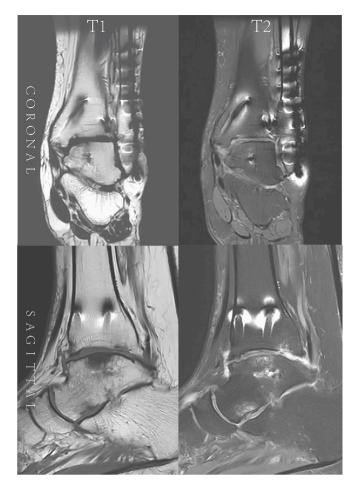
A recent 4-year MRI showed satisfying healing between graft and surrounding talus.
